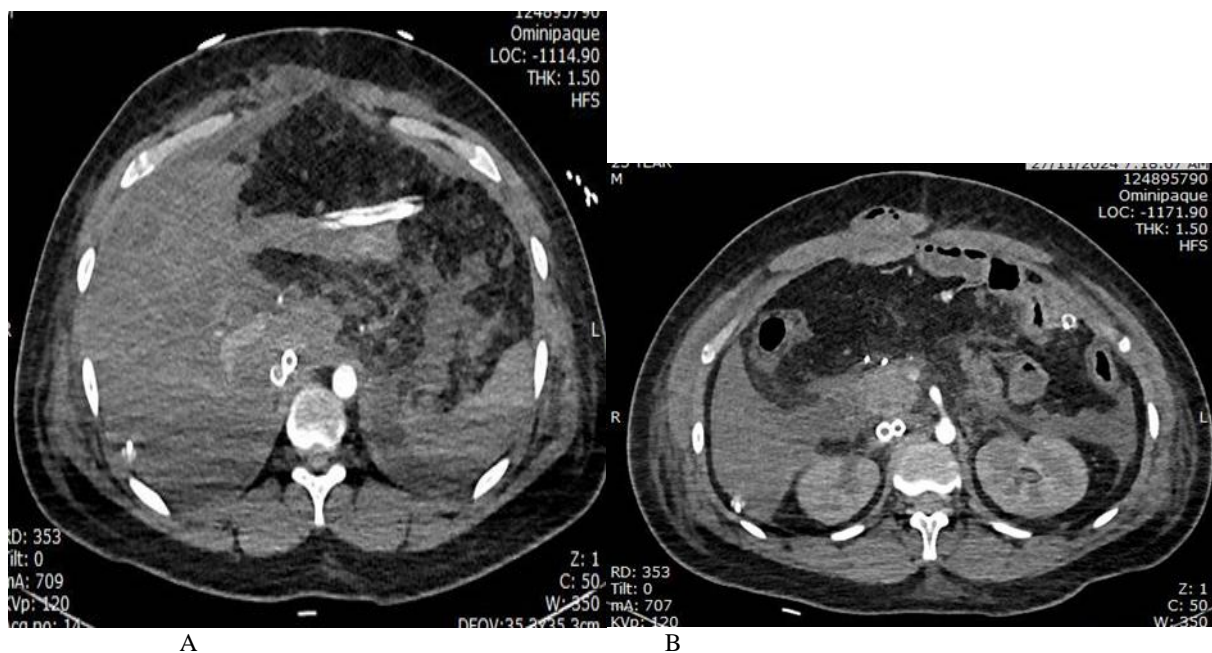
A, B: Follow up Contrast enhanced CT after 3 days shows abdominal drain, right subphrenic and echmo catheter in IVC. Regression of peri hepatic collections measuring about 30.0 ml, and perisplenic collection about 135.0 ml.
